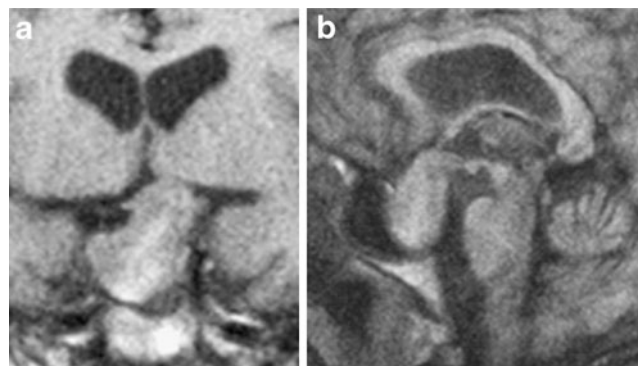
T1-weighted MR imaging of case 5 (a coronal view, b sagittal view) showing a large intrasellar cystic mass with suprasellar and right cavernous extension
